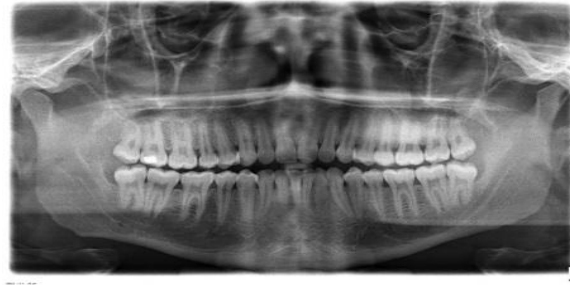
Digital Panoramic x-ray
